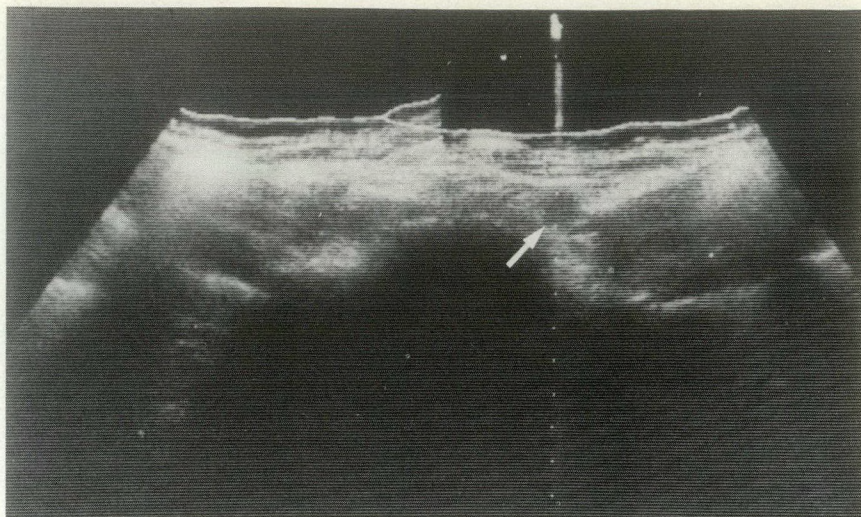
Transverse sonogram demonstrates 2-cm echo-poor nodule (arrow) in retroperitoneum below pelvic brim.
